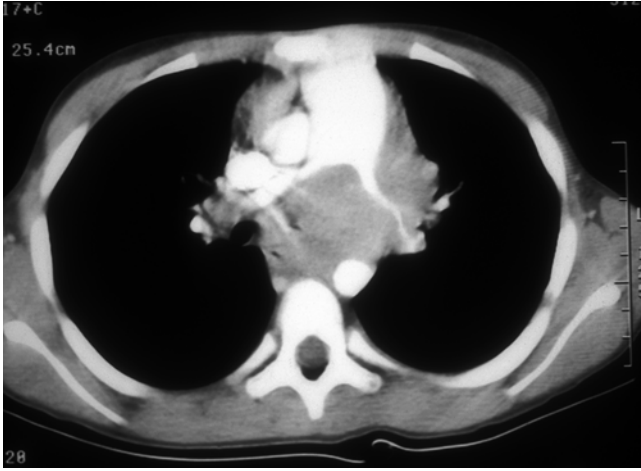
This CT scan of an 8 year old boy who presented with a cough shows a large lesion arising in the hilum of the lung and extending into the mediastinum surrounding the left pulmonary artery. Needle biopsy demonstrated a bronchogenic carcinoma which had a rapidly progressive course despite intensive chemotherapy
